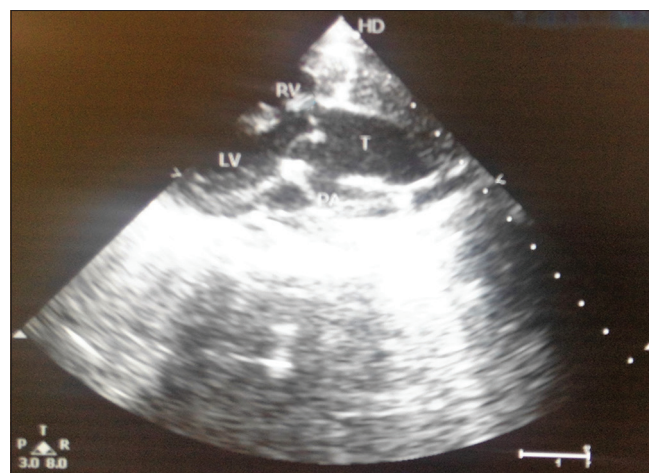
Long-axis parasternal view showing truncal vessel and pulmonary artery
